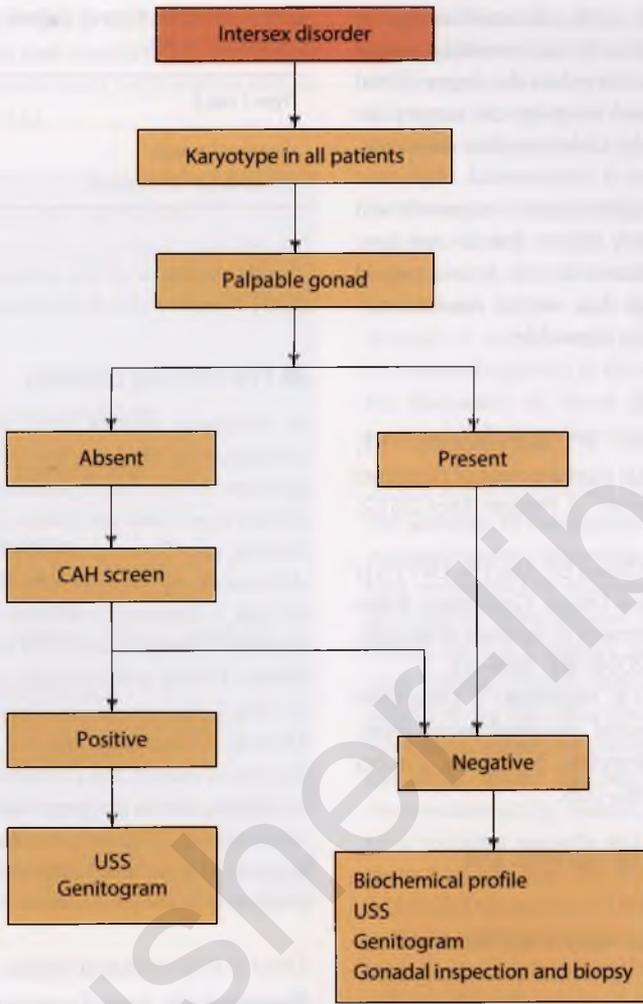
Laboratory and imaging studies in newborns with genital anomaly. CAH, congenital adrenal hyperplasia; USS, ultrasound scan.
